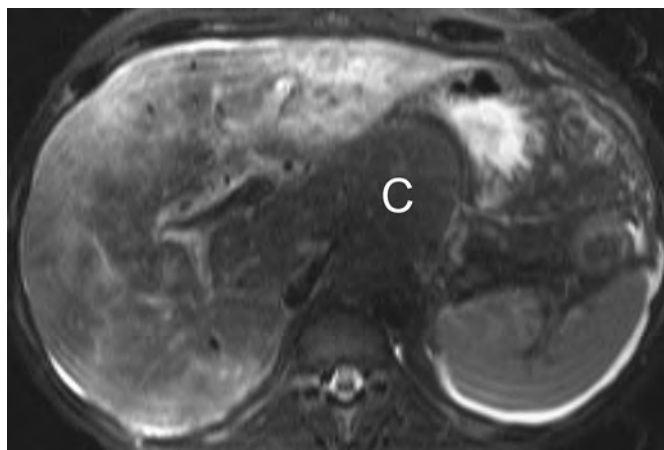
Subacute Budd-Chiari syndrome: MRI findings. T2-weighted MR image shows caudate lobe (C) hypertrophy. The periphery of the liver is hyperintense, indicating edema. There is a small amount of ascites.
